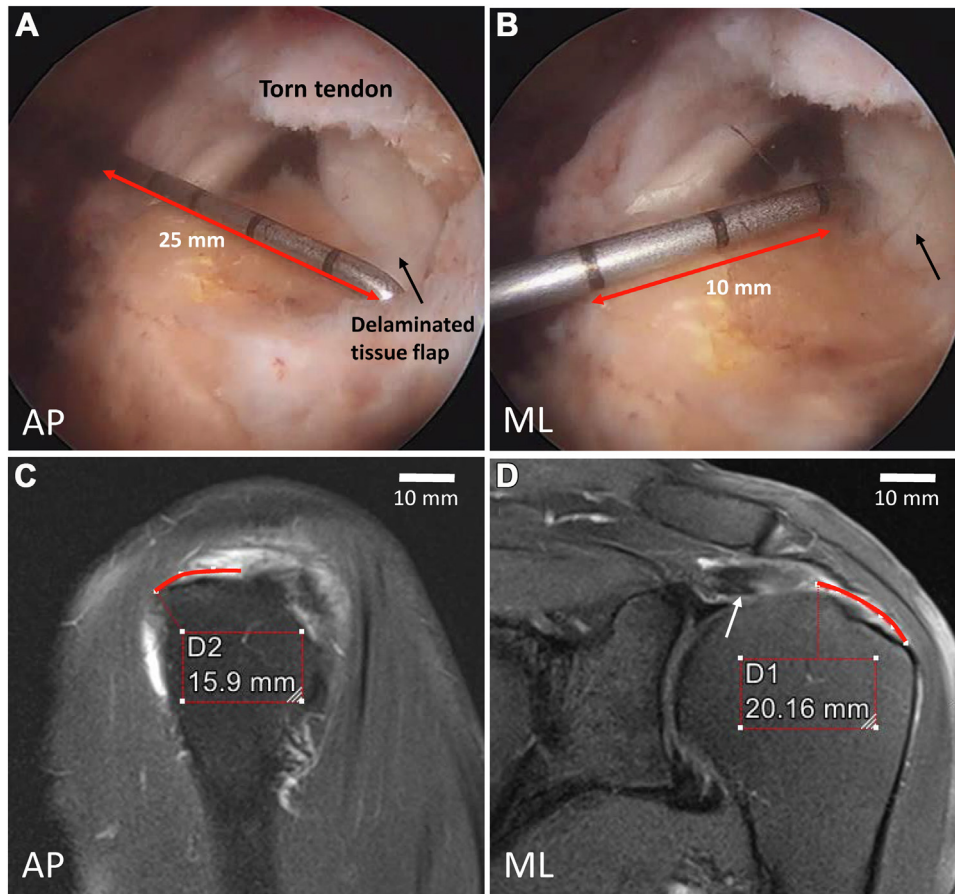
Examples of operative and MRI measurements to demonstrate the 2 measurement techniques in the same patient. An arthroscopic straight-hook surgical probe with 5-mm calibrated markings was used for measuring (A) AP and (B) ML tear dimensions intraoperatively (after débridement). On preoperative MRI, the PACS software was used for (C) AP and (D) ML measurements. MRI, magnetic resonance imaging; AP, anterior-posterior; ML, medial-lateral; PACS, picture-archiving and communication system (TeraRecon, Inc. Durham, NC, USA).
